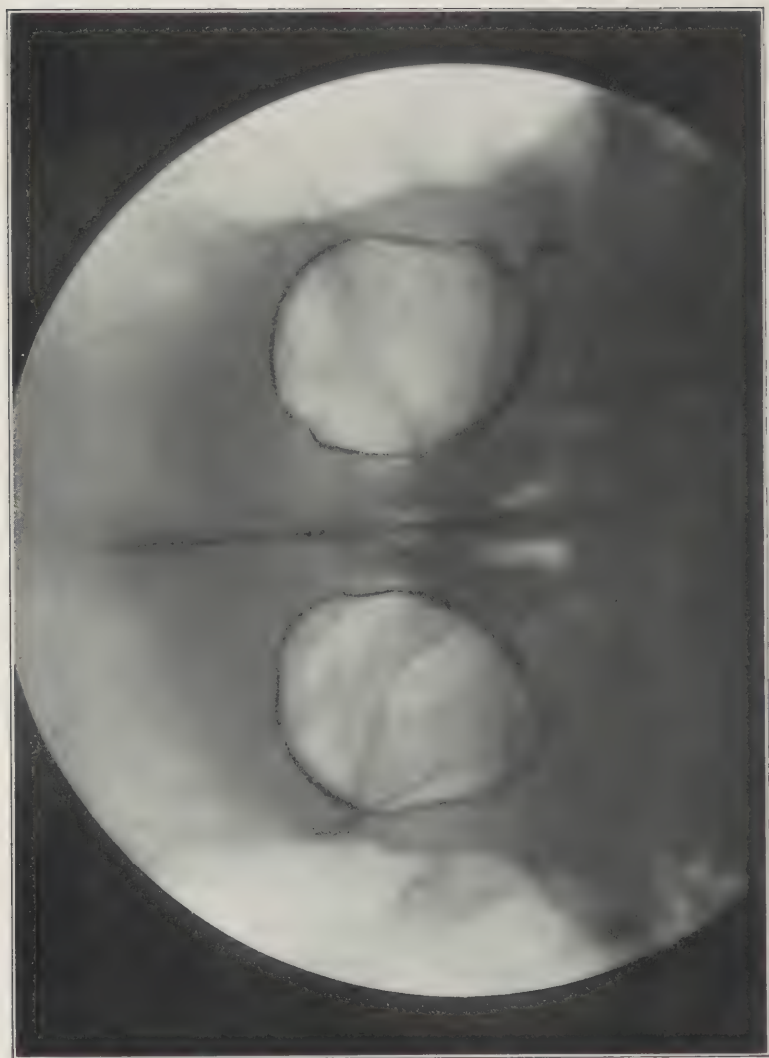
An X-ray plate showing absence of the frontal sinuses.
